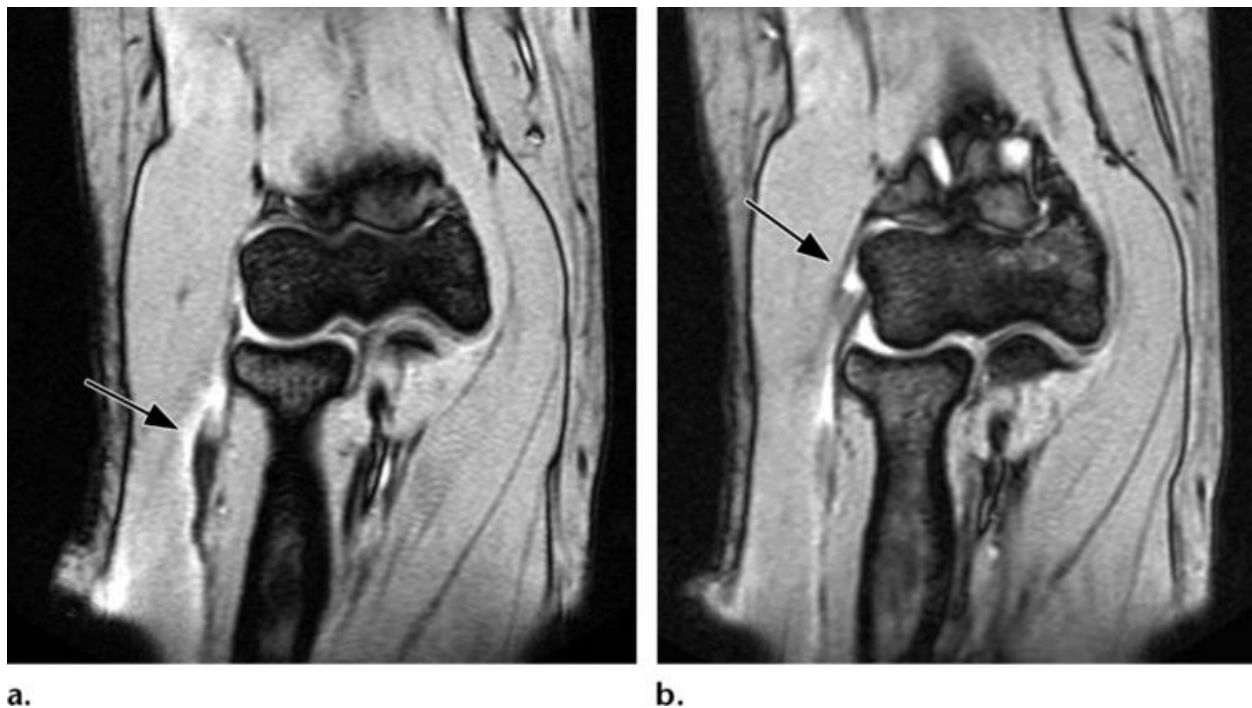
LE in severe form. (a) A 40-year-old woman's coronal GRE MR scan shows a full-thickness tear and retraction of ECRB with nearby edema (arrow). (b) Location of anticipated ECRB tendon origin is indicated by a fluid-filled gap (arrow) in the coronal GRE MR image at level of lateral epicondyle.²⁹
